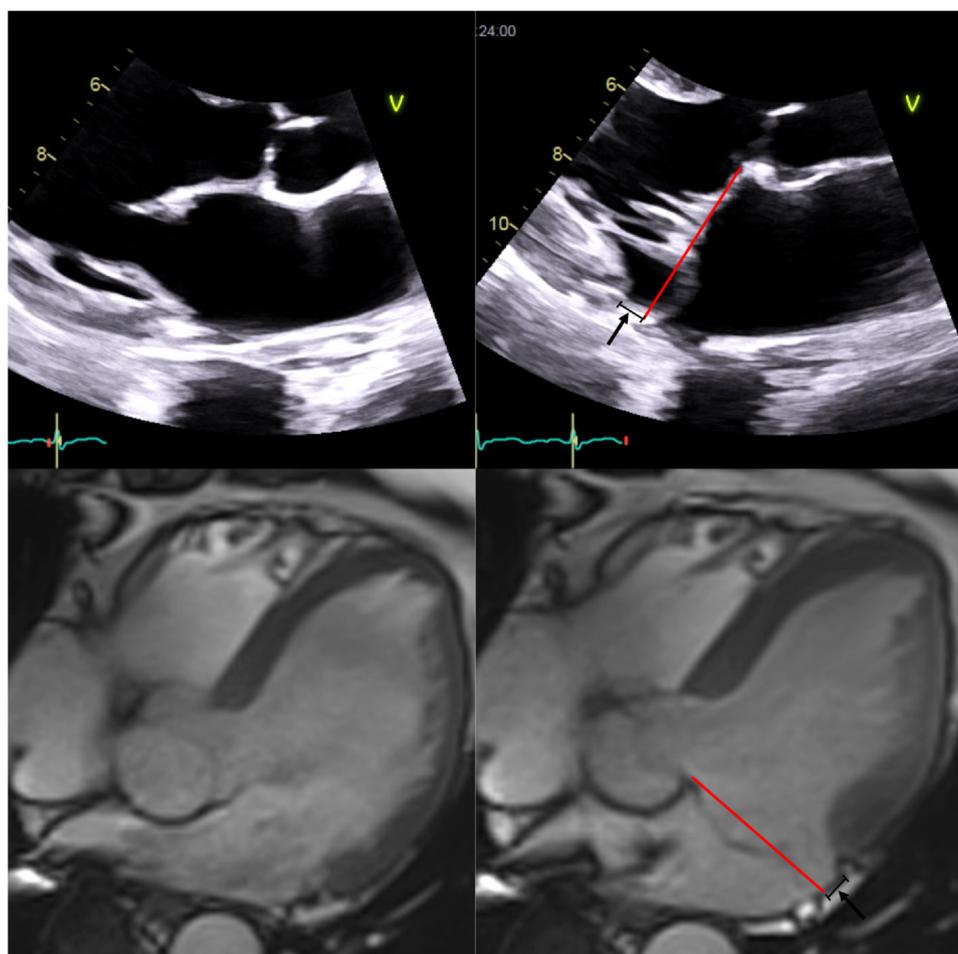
Mitral valve prolapse and mitral annulus disjunction by transthoracic-echocardiography and cardiovascular magnetic resonance (CMR). Transthoracic-echocardiographic long-axis view in end-diastole displaying the mitral valve without MAD (upper left), and in end-systole with myxomatous posterior leaflet prolapse and MAD of 5 mm length (upper right). CMR three-chamber view in mid-diastole displaying the mitral valve without MAD (lower left), and in end-systole with bi-leaflet mitral valve prolapse and MAD of 4 mm length (lower right). MAD mitral annular disjunction
